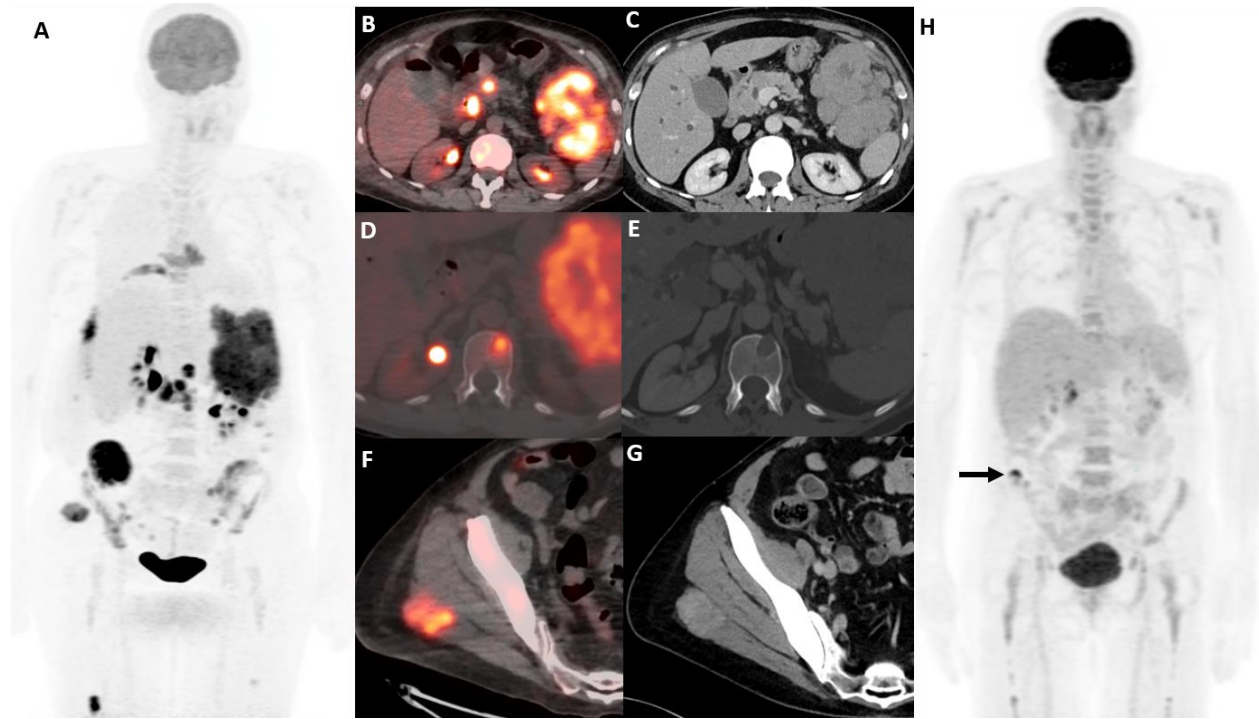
On the staging F18-FDG PET/CT MIP image (A), there are multiple hypermetabolic metastases, including an obstructive pancreatic head mass, large left upper quadrant mass, lytic lesion in the T12 vertebral body, and right gluteus maximus muscle lesion on PET/CT fusion (B, D & F) and corresponding contrast enhanced diagnostic CT (C, E, G). After three cycles of chemotherapy, follow-up F18-FDG PET/CT showed near-complete response and a small residual tracer-avid focus in the right iliac wing (arrow in H).
